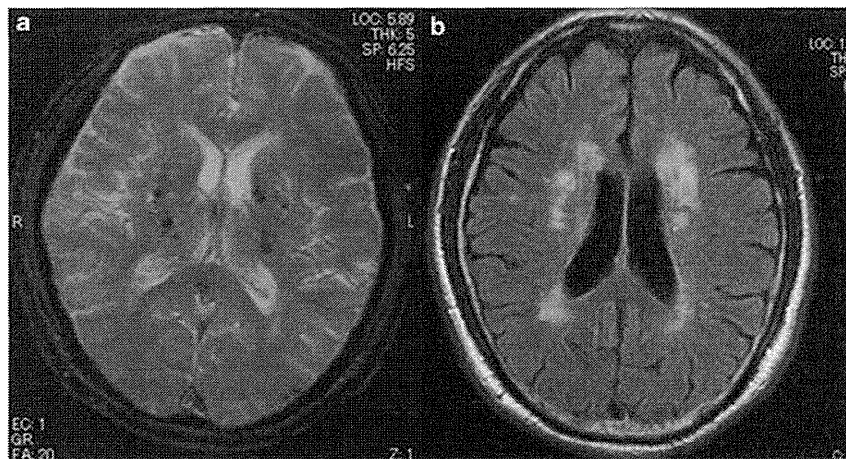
MRI scan of the brain of a 73-year-old male patient with lacunar infarction and a CAVI of 11.5. (a) A T2*-weighted gradient echo image shows multiple CMBs in the bilateral basal ganglia. (b) A FLAIR image shows advanced WMH. CAVI, cardio-ankle vascular index; CMBs, cerebral microbleeds; FLAIR, fluid-attenuated inversion recovery; WMH, white matter hyperintensity.
